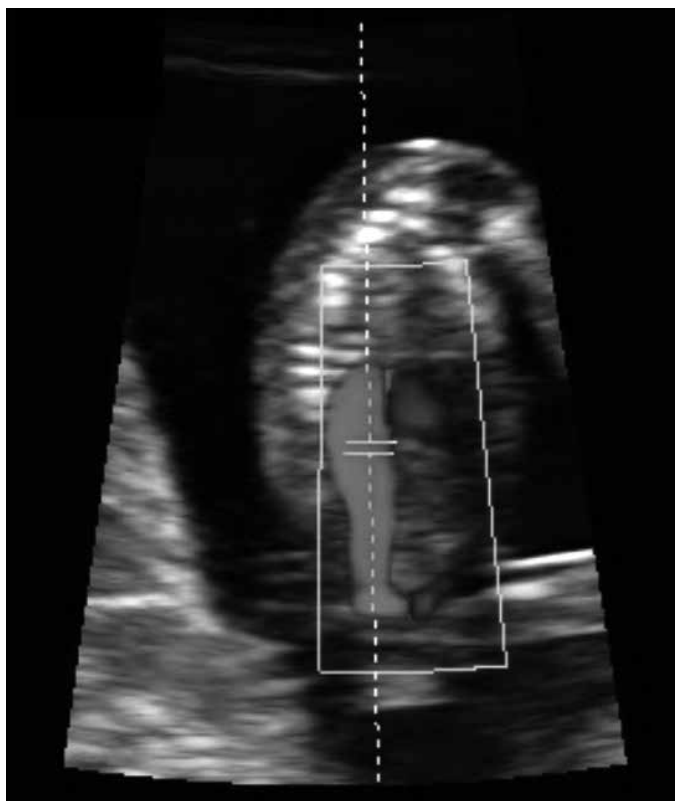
First trimester fetal aortic Doppler
